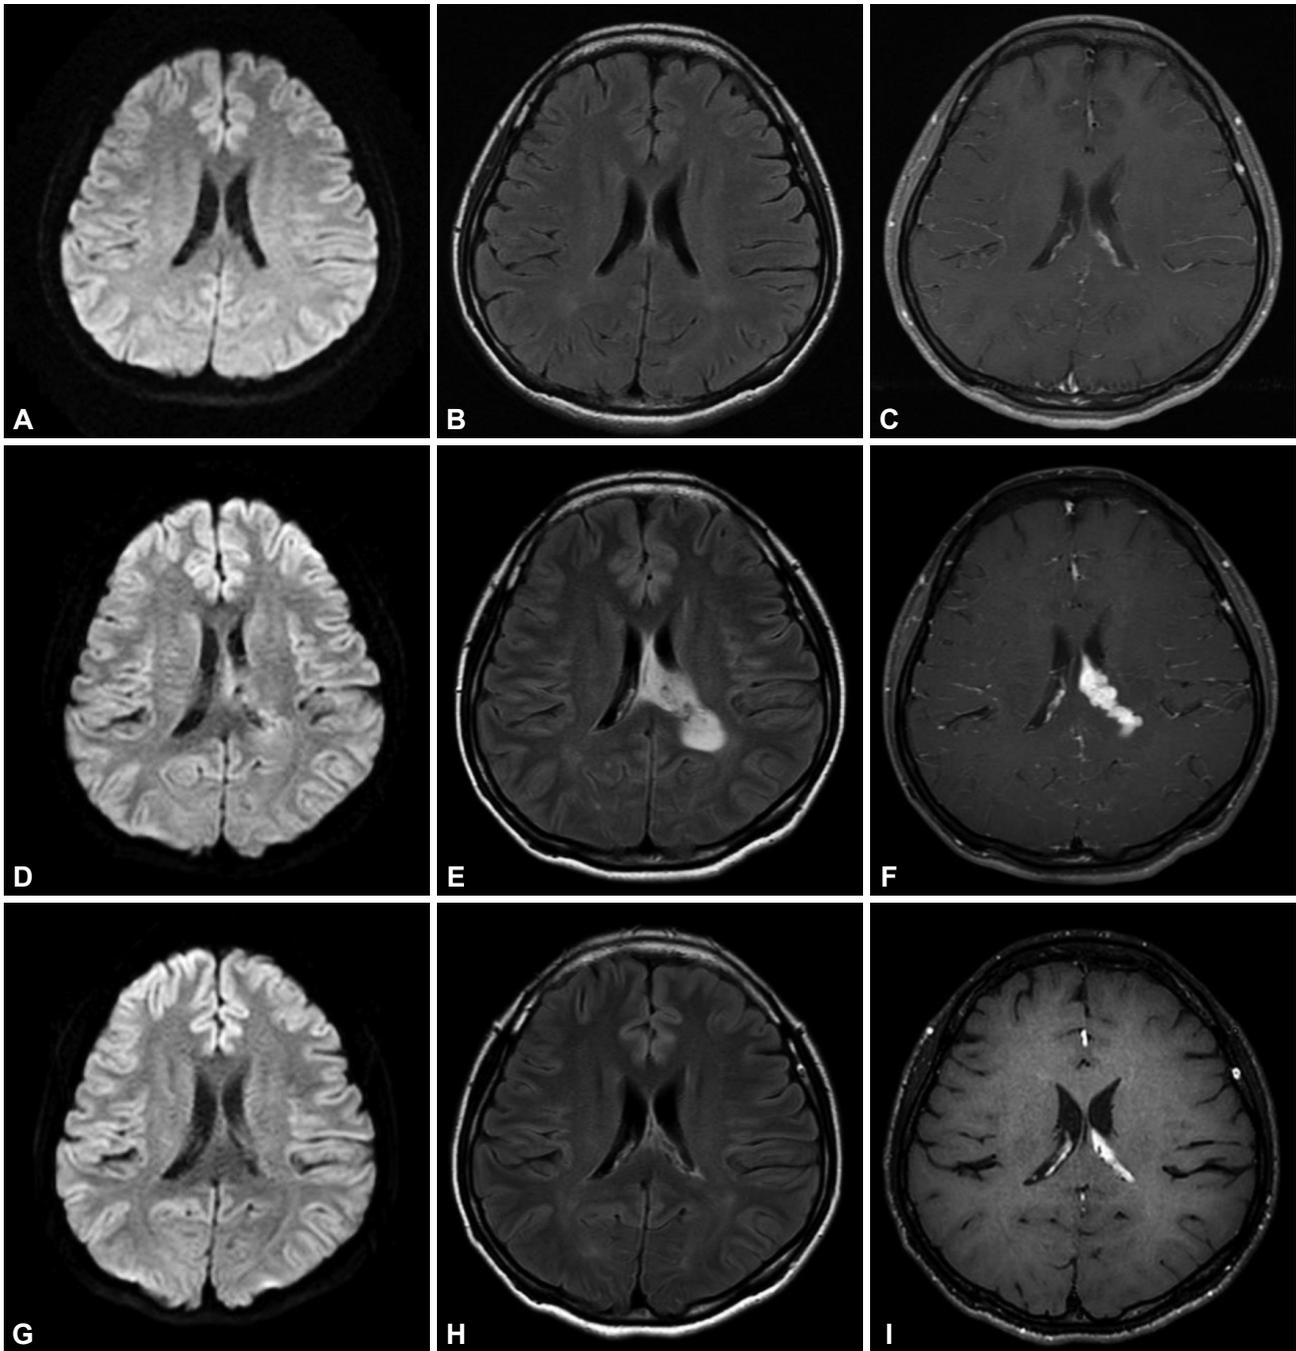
MRI changes in paradoxical choroid plexitis. Serial diffusion-weighted imaging, FLAIR, and gadolinium-enhanced T1-weighted images from an axial view. A–C: Initial images showing diffuse leptomeningeal enhancement. D–F: Follow-up neuroimaging for severe headache performed 5 weeks after initiation of antituberculosis medication demonstrates left choroid plexitis. G–I: Follow-up images obtained in the sixth month, indicating marked improvement of the lesion and confirmation of a paradoxical reaction.
